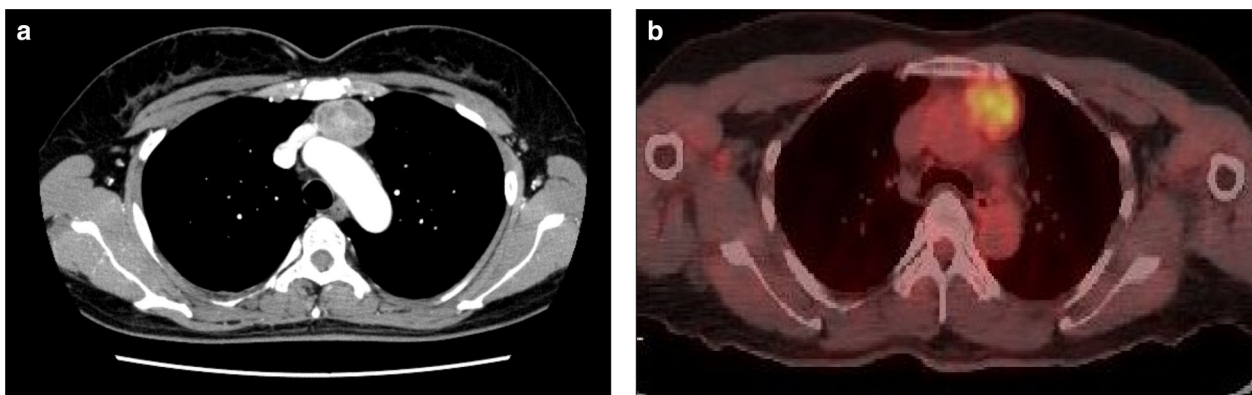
(a) Chest computed tomography showed an anterior mediastinal mass and (b) the mass was positive on positron emission tomography with ^{18}F -fluorodeoxyglucose-positron emission tomography/computed tomography (18-FDG-PET/CT)
